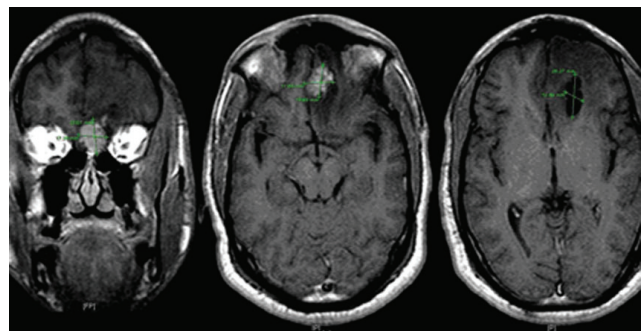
MRI of the brain with contrast showing a necrotic mass with irregular enhancement.
